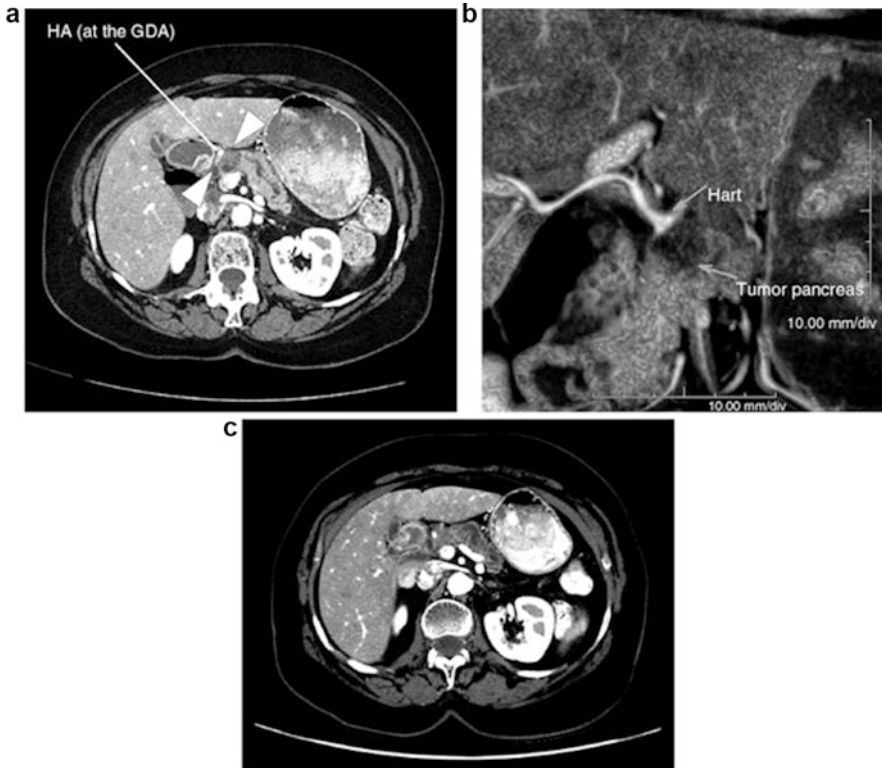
Pre and posttreatment CT scans of a 74-year-old patient presenting with short-segment involvement of the hepatic artery (HA) at the level of the gastroduodenal artery (GDA). (a) Pretreatment scan shows tumor (white arrowhead) involving the HA; (b) the scans showed a 1.6 cm hypodense mass that was inseparable from the RHA and proximal GDA at the bifurcation as seen in the coronal view. The left HA was noted to arise from the left gastric artery. Patient was treated with capecitabine-based chemoradiation for a total dose of 50.4 Gy in 28 fractions; (c) postchemoradiation scan shows persistent hepatic arterial involvement. Patient underwent an R0 pancreaticoduodenectomy with resection of the hepatic artery with primary repair. Pathology showed a residual moderately differentiated ductal adenocarcinoma (1.7 cm) with perineural and lymphovascular invasion. Tumor was 1.1 cm from the retroperitoneal margin. Eighteen regional lymph nodes were removed and all were negative for micrometastatic disease. Patient completed adjuvant single agent gemcitabine chemotherapy, and interim CT scan showed no evidence of disease 1 year following pancreaticoduodenectomy
